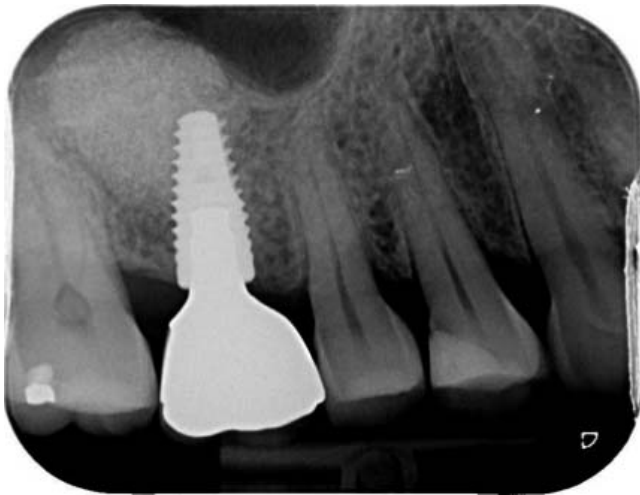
Peri-apical radiograph of the implant 1 year after simultaneous MSA and implant insertion (Patient 1).
